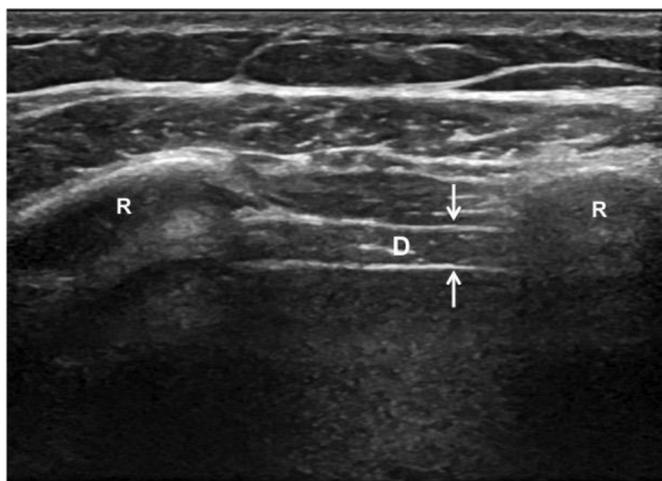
Ultrasound imaging of the diaphragm
